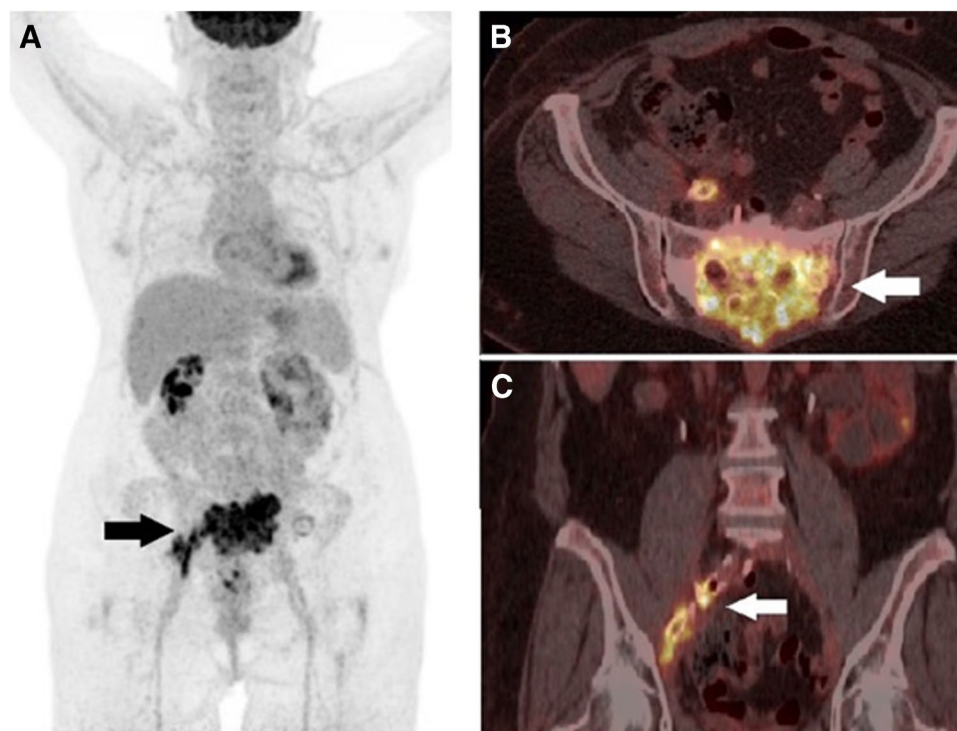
An example of the fast protocol. A 65-year-old-female, affected by severely debilitating skeletal metastasis of the pelvis from anal cancer, previously submitted to vascular endoprostheses of the right iliac artery, scheduled for restaging PET/CT. Supine posture was uncomfortable due to intense pelvic pain; therefore, after i.v. administration of 3.7 MBq/kg of [^{18}F]FDG, a fast protocol was used for digital PET/CT (Siemens Biograph Vision 450), with an axial FOV of 19.7 cm using continuous-bed motion with a bed speed equivalent
